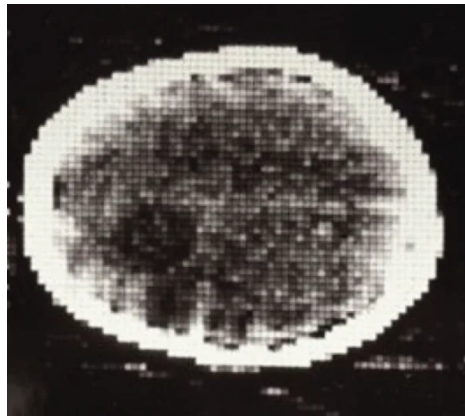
First image of a brain tumor using a CT scanner. Source: [156], CC BY.
